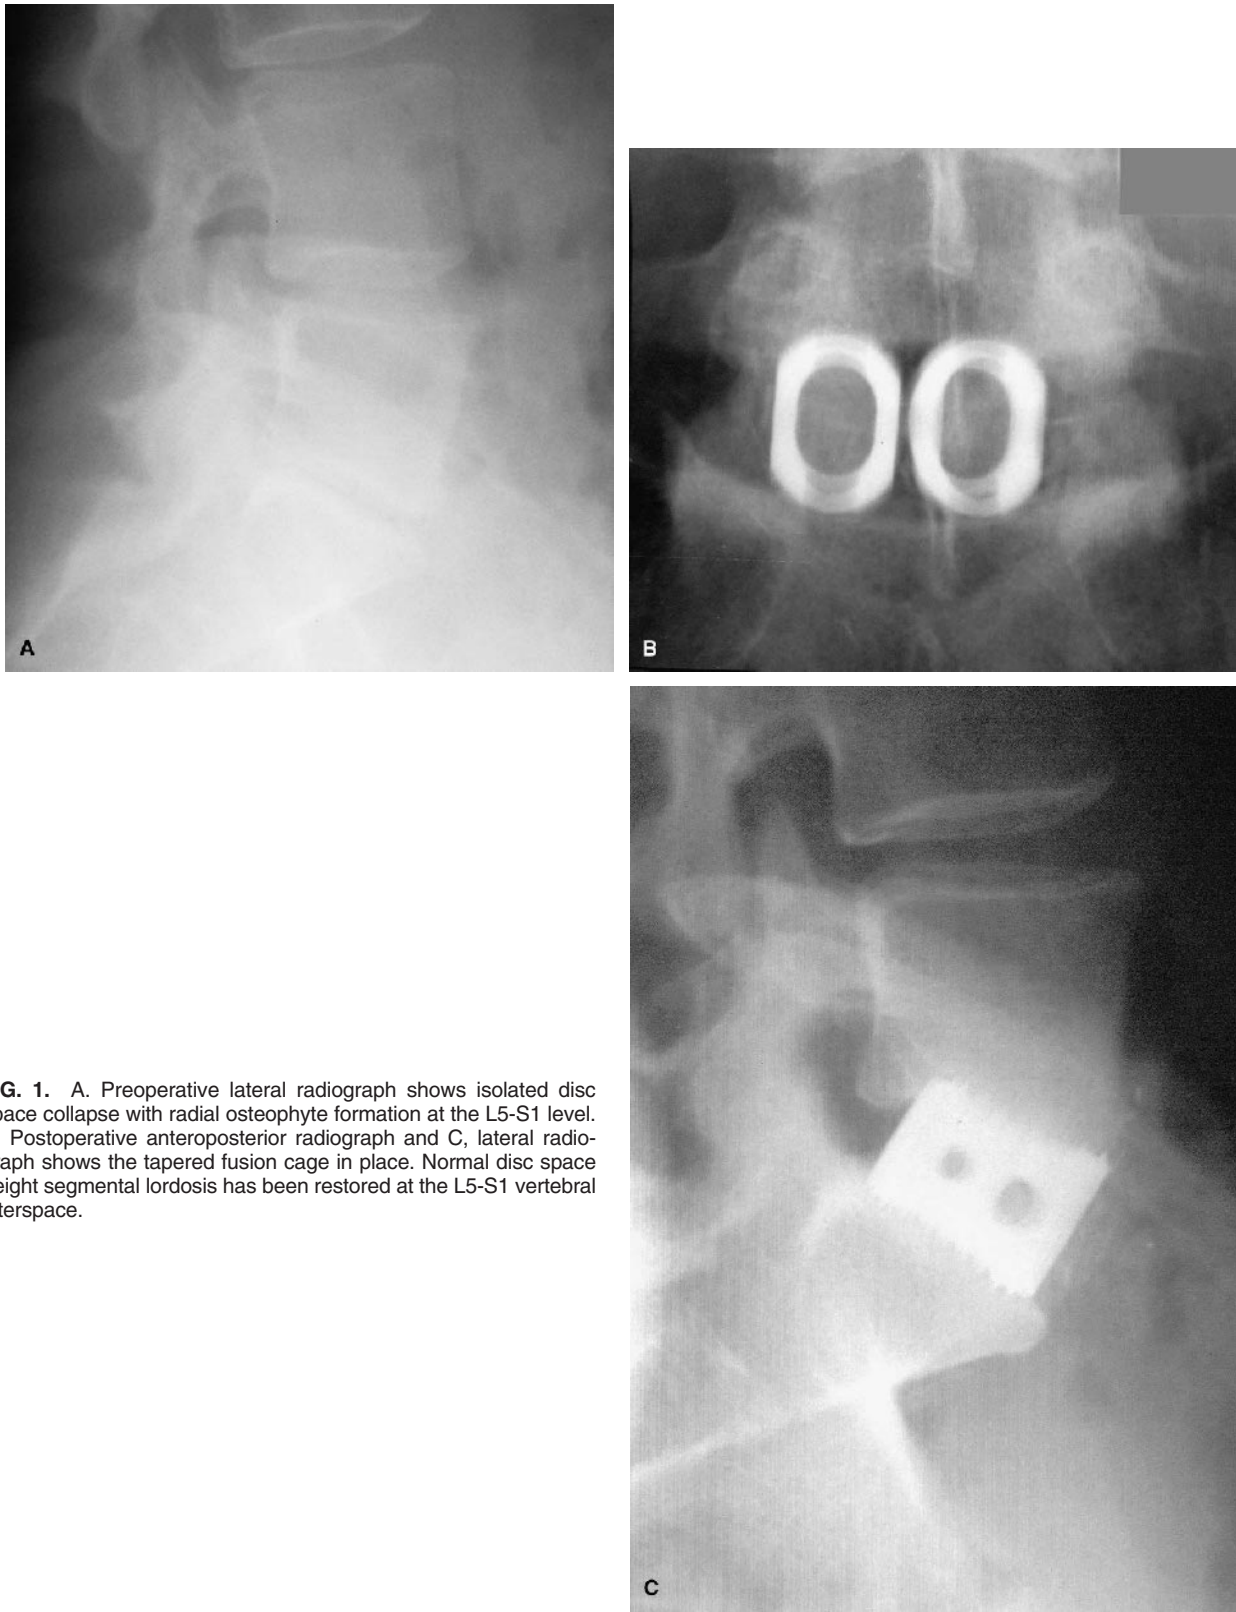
A. Preoperative lateral radiograph shows isolated disc space collapse with radial osteophyte formation at the L5-S1 level. B. Postoperative anteroposterior radiograph and C, lateral radiograph shows the tapered fusion cage in place. Normal disc space height segmental lordosis has been restored at the L5-S1 vertebral interspace.
